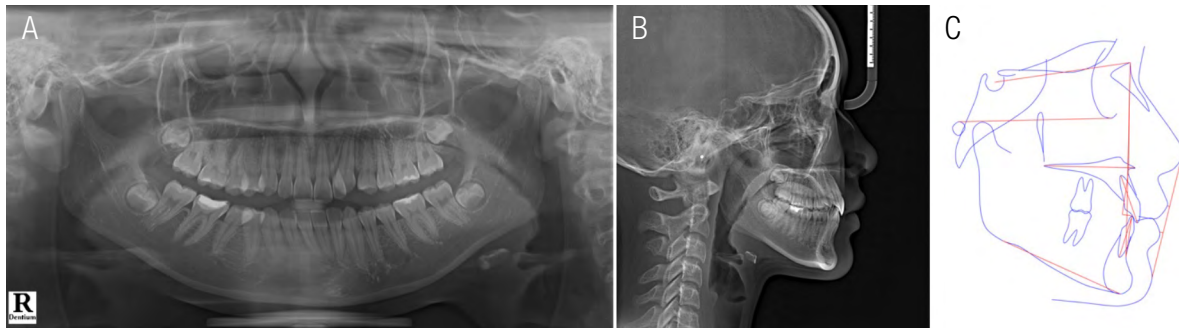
Panoramic radiograph(A), lateral cephalometric radiograph (B), and tracing (C) before orthodontic treatment.
